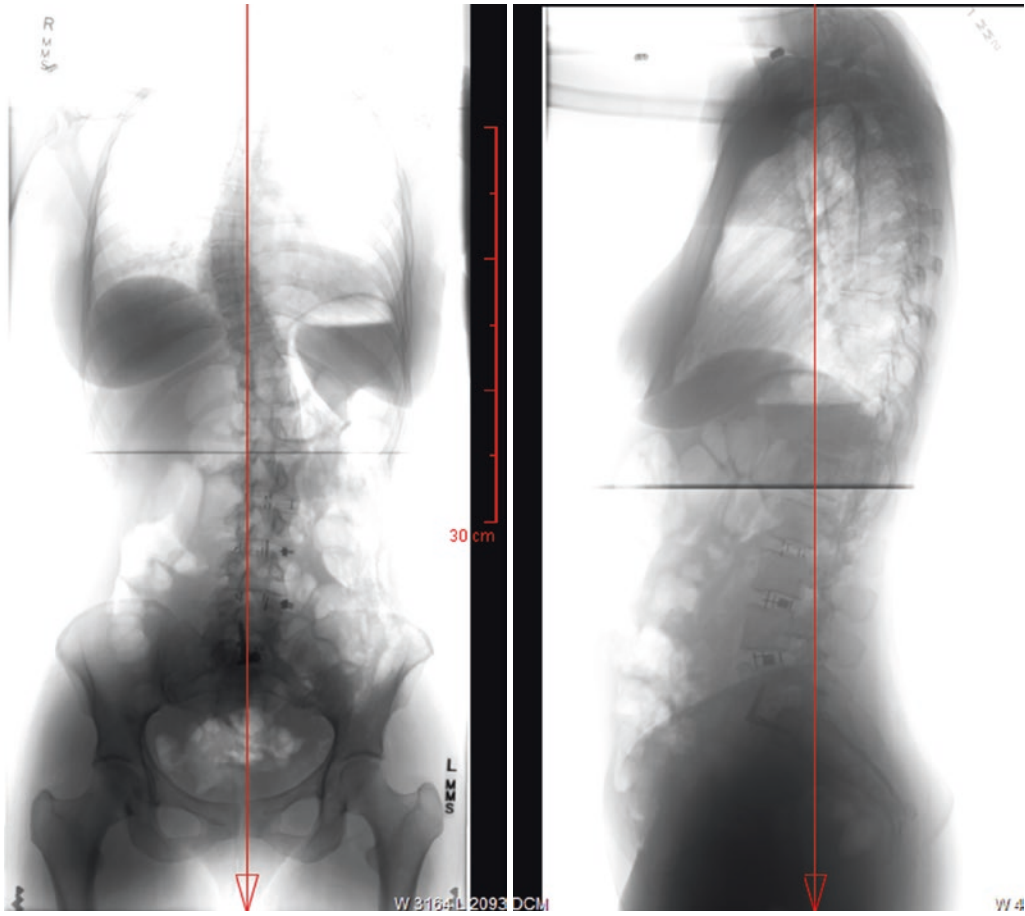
Postoperative AP and Lateral Scoliosis X-rays after anterior reconstruction demonstrate OLIFs L2-sacrum, excellent correction of coronal and sagittal deformity, and reduction of spondylolisthesis
